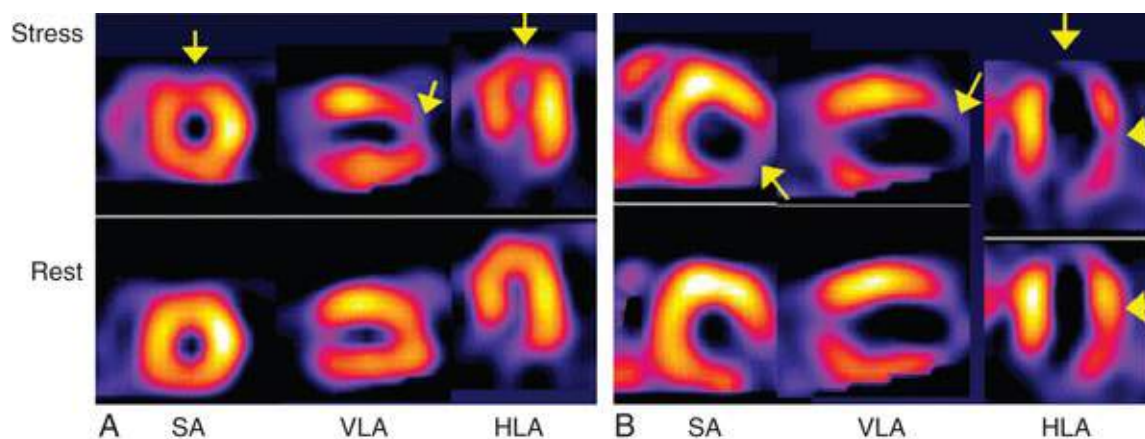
A, Example of SPECT anterior and apical reversible perfusion defects (*arrows*), representing inducible regional myocardial ischemia in short-axis (SA), vertical long-axis (VLA), and horizontal long-axis (HLA) views. B, Example of irreversible or fixed defects of inferolateral wall on SA images and of apex on VLA images (*arrows*), representing predominant myocardial infarction. On HLA image, evidence of a reversible lateral wall defect (*arrows*) representing lateral wall ischemia also is seen.
